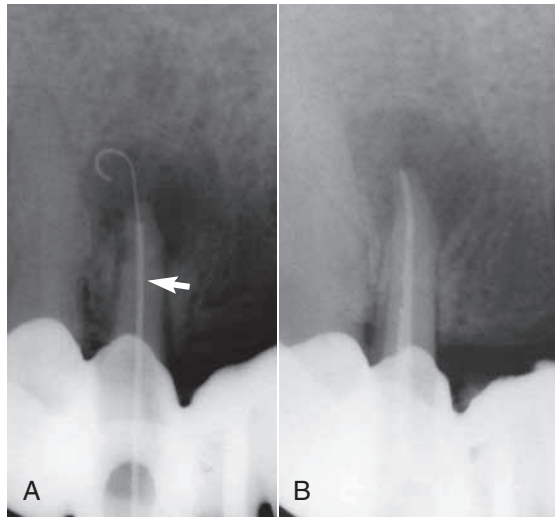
Apexum in clinical use. A, The Coarse Apexum Ablator in a periapical lesion of an upper single rooted tooth. Note the sheath in the root canal (*arrow*). B, Root canal obturation (lateral condensation) immediately after the Apexum procedure has been completed.²⁵⁸ (Courtesy Apexum, Or-Yehuda, Israel.)
